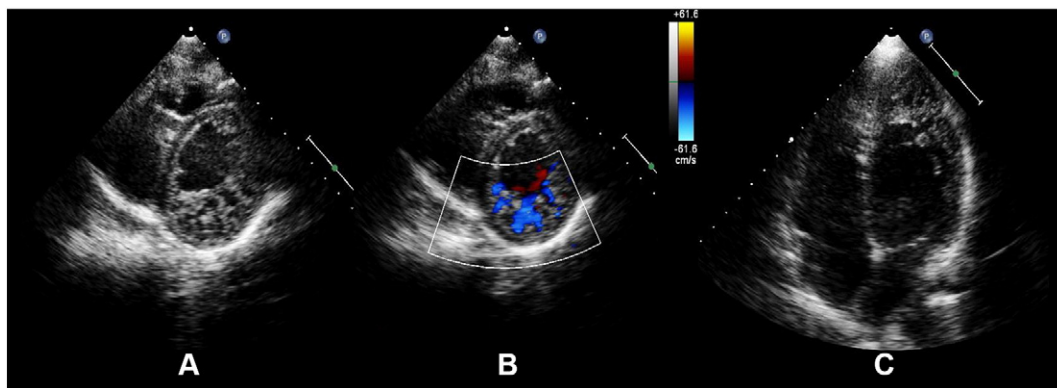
Echocardiographic images from a 33 year-old male Caucasian cyclist. Short axis images (A and B) show the double layer appearance of the LV ventricle in end-diastole with a thin epicardial layer and a thicker and hypertrabeculated endocardial layer with evidence of color Doppler filling the recess from the LV cavity (B). Panel C shows the 4-chambers view; the athlete had impaired LV systolic function with ejection fraction of 45%. The Chin index was 0.26 and Jenni index was 2.20; the LV compact layer measured 4 mm in diastole and 5 mm in systole. Due to LV dysfunction he was restricted from training and competition and entered a periodic follow-up program.
